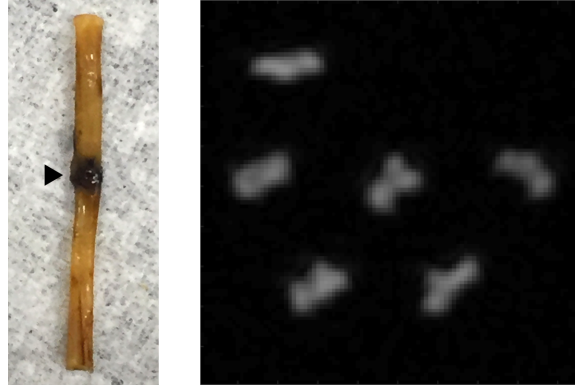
Excised sciatic nerve imaging. (Left) Representative injured sciatic nerve with injury site indicated by a black arrow. (Right)  $T_2$ -weighted image of 6 sciatic nerves in the transverse plane, demonstrating the MR imaging setup.
